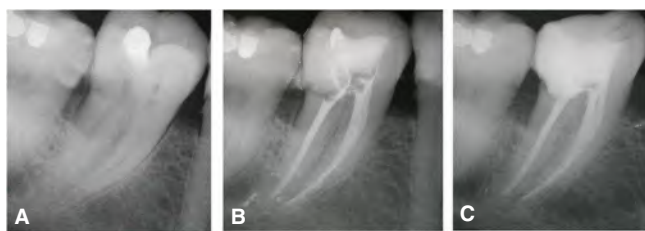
Nonsurgical endodontic treatment following pulp necrosis in a mandibular second molar of a 32-year-old male. A. Preoperative radiograph showing occlusal and distal coronal restorations. B. Immediate postoperative radiograph. C. Five-year follow-up radiograph showing normal appearance of the periradicular tissues.
